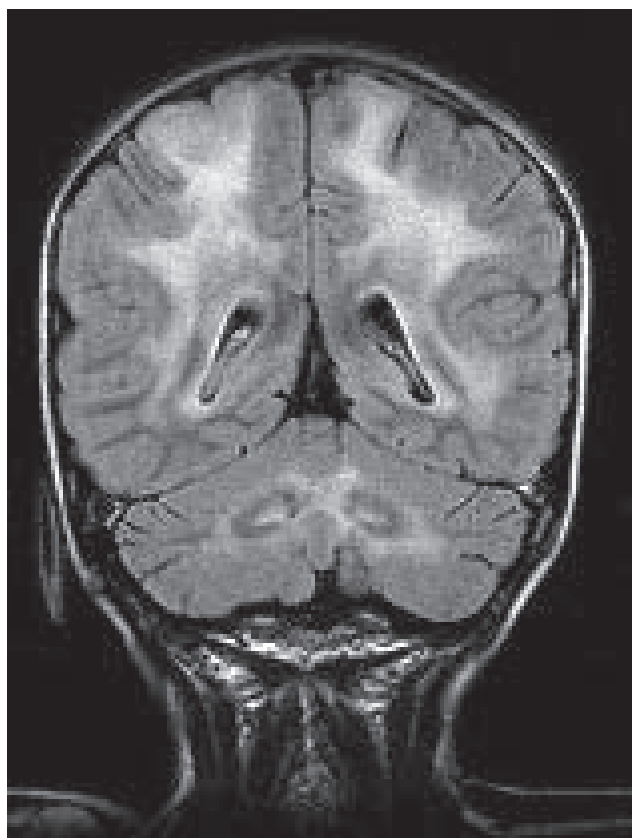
MRI of patient 6 with juvenile form. lesions in the hili of dentate nucleus and cerebellar white matter apart of cerebral white matter. FLAIR sequence.
